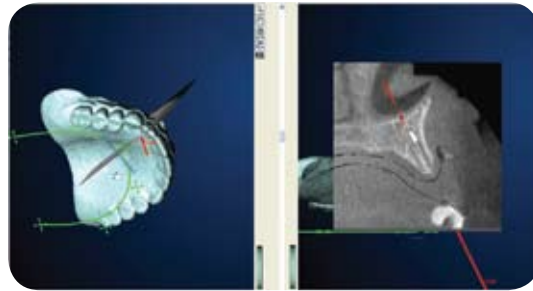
Three-dimensional view of surgical guide with implant trajectory and cross sections. (Images created in Nobel Biocare's ProCera Software, C-Dental X-Ray, Inc.)
